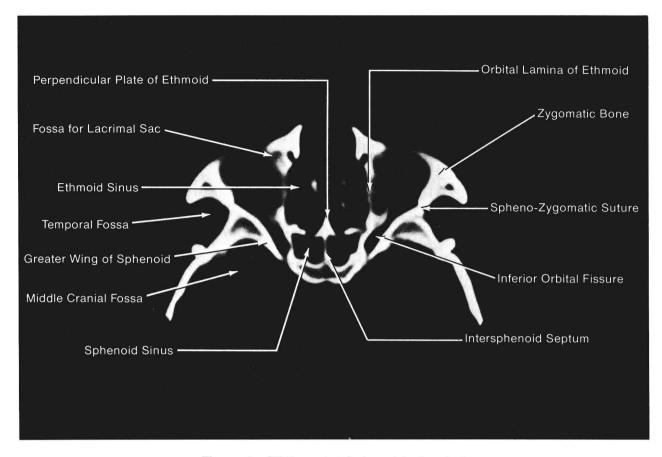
CT through inferior orbit of a skull.
